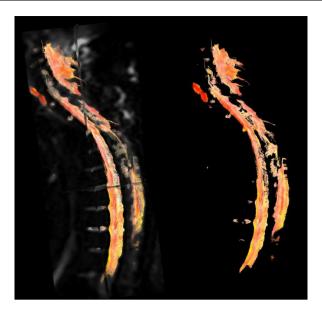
Postoperative cervical and thoracic MRI tractography shows the preservation and continuity of most of the fibers with partial destruction in the posterior part, predominantly at the levels of Th2 and Th3 of spinal cord.
